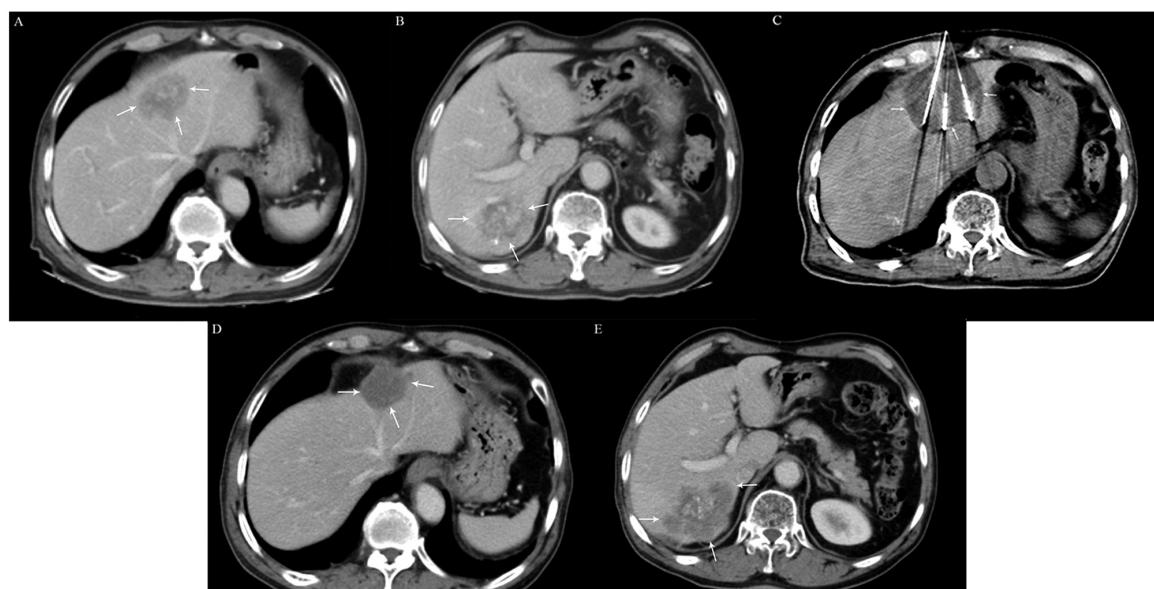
A patient with multiple metastatic liver adenocarcinoma from sigmoid colon received percutaneous cryoablation for the lesion of left lobe liver. Several times of TACE were received previously. Axial contrast-enhanced CT image in the portal venous phase demonstrates the metastatic lesion of left lobe liver (a, arrow) which intended to receive percutaneous cryoablation and another metastatic lesion of right lobe liver (b, arrow) which intended to handle afterward. Axial CT image (c) during cryoablation demonstrates a suitable position of cryoprobes and a big enough ablated range. But this patient experienced agnogenic thrombocytopenia after cryoablation, and he refused to receive cryoablation once more for the lesion of right lobe liver. After one time of microwave ablation for the lesion of right lobe liver and one time of TACE, during 203 days from cryoablation to CT reexamination, axial contrast-enhanced CT image in the portal venous phase demonstrates a stable condition for the ablated lesion of left lobe liver which received cryoablation (d, arrow) and a tumor progression condition for the ablated lesion of left lobe liver which received microwave ablation (e, arrow).
